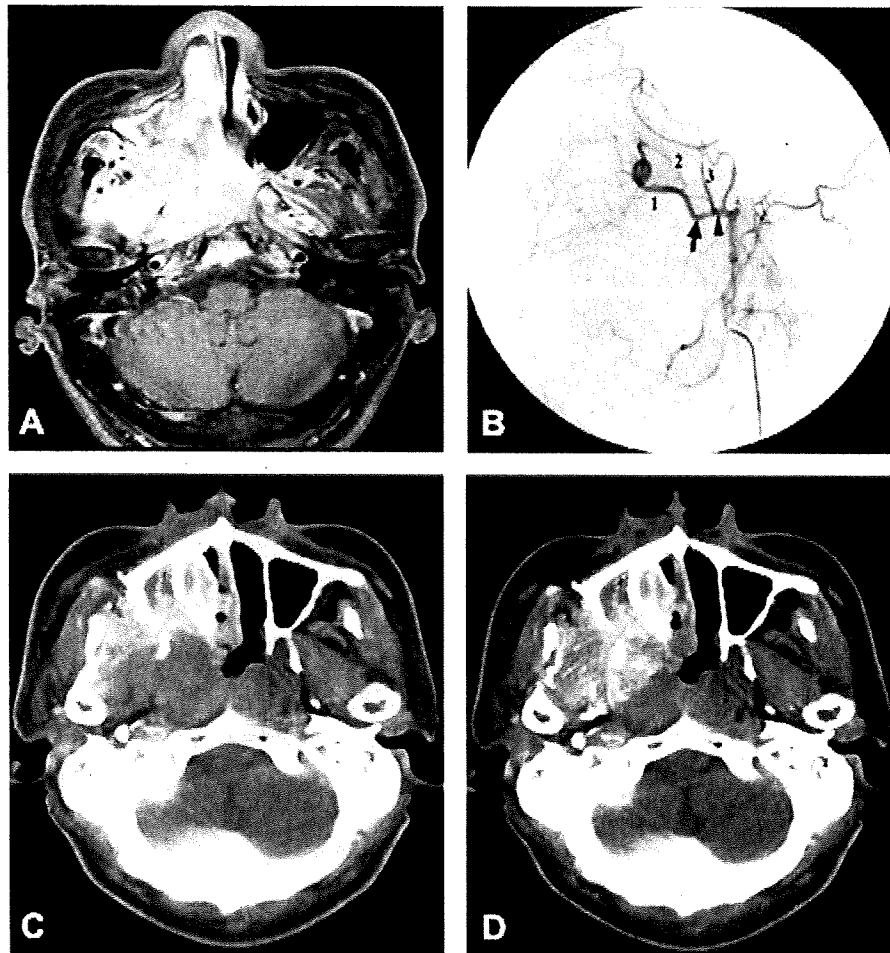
(A) Findings from a 57-year-old man with a right maxillary sinus cancer that was classified as T4bN2bM0 are shown. (B) A lateral subtraction angiogram of right external carotid artery is shown. The internal maxillary artery (indicated by 1), accessory meningeal artery (indicated by 2), and middle meningeal artery (indicated by 3) are shown. (C) Intra-arterial computed tomographic arteriography (IA-CTA) was performed after a microcatheter was placed just beyond the middle meningeal artery (arrow in Fig. 1B). The IA-CTA demonstrated a tumor with enhancement in the anterior but not posterior portion. (D) The catheter was then placed just in front of the middle meningeal artery (arrowhead in Fig. 1B). IA-CTA indicated that the majority of the tumor was enhanced at this time. The posterior portion of the tumor was considered to be covered by the accessory meningeal artery.
